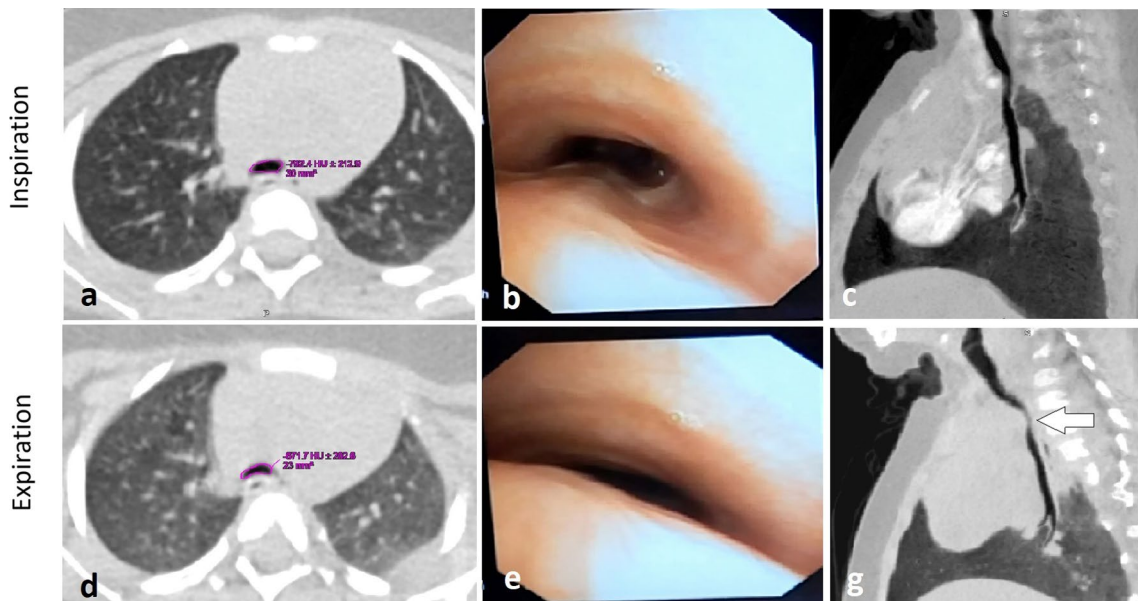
Expiratory central airway collapse at aortic arch level. Cross-sectional area measurement of trachea at aortic arch level using cine CT during end-inspiratory (a) and end-expiratory phases (d) revealed significant expiratory airway collapse that was calculated to be 60% cross-sectional area reduction. Corresponding flexible bronchoscopy images are shown (b, e) confirming the presence of significant expiratory airway collapse with almost the same degree perceived by CT. Sagittal MinIP images (c, g) shows the significant expiratory airway collapse at the same level (arrow)
